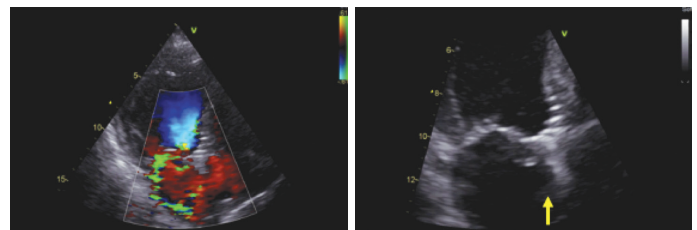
Echocardiography at 48th day.
